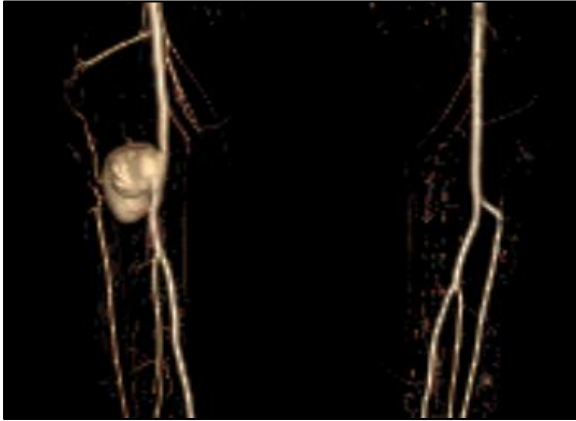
CT angiogram showing an aneurysm in the distal popliteal artery with the anterior tibial artery arising from aneurysm.
